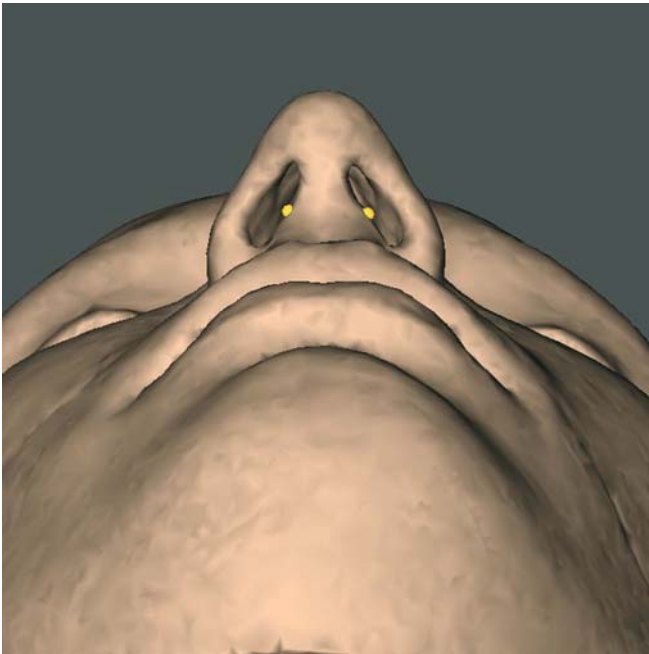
Subnasale'_r and subnasale'_l, Base view (3-D CT, patient K.C.)
